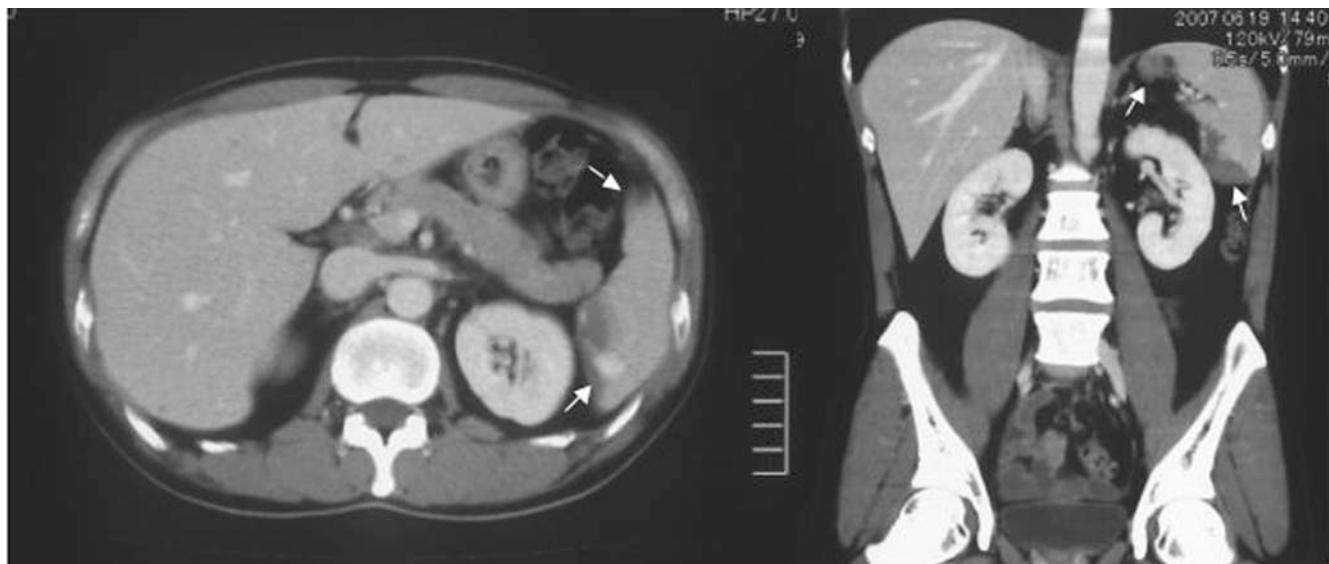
Abdominal computed tomography on admission showed two low-attenuation areas, suggestive of infarctions, in the spleen (arrows)
